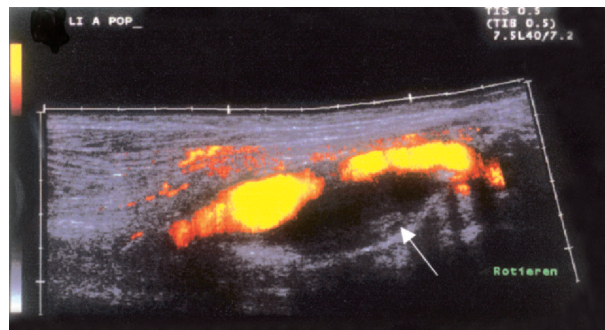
Extended field-of-view in power Doppler US: partially thrombosed aneurysm of the popliteal artery. The arrow marks the thrombosed part of the aneurysm, extended field-of-view US in power Doppler US enables a better morphological overview.
